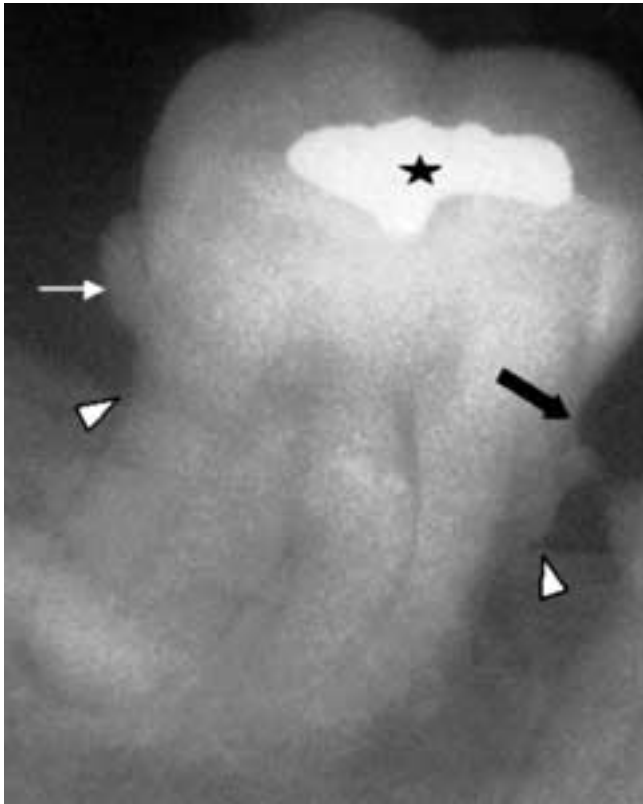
Periapical radiograph depicts moderate loss of alveolar bone (*arrowheads*). Cementoenamel junction (*black arrow*). The star denotes the occlusal amalgam dental restoration. Adherent calculus (tartar), which is frequently seen with periodontal disease, surrounds the clasp of the removed partial denture (*white arrow*).
